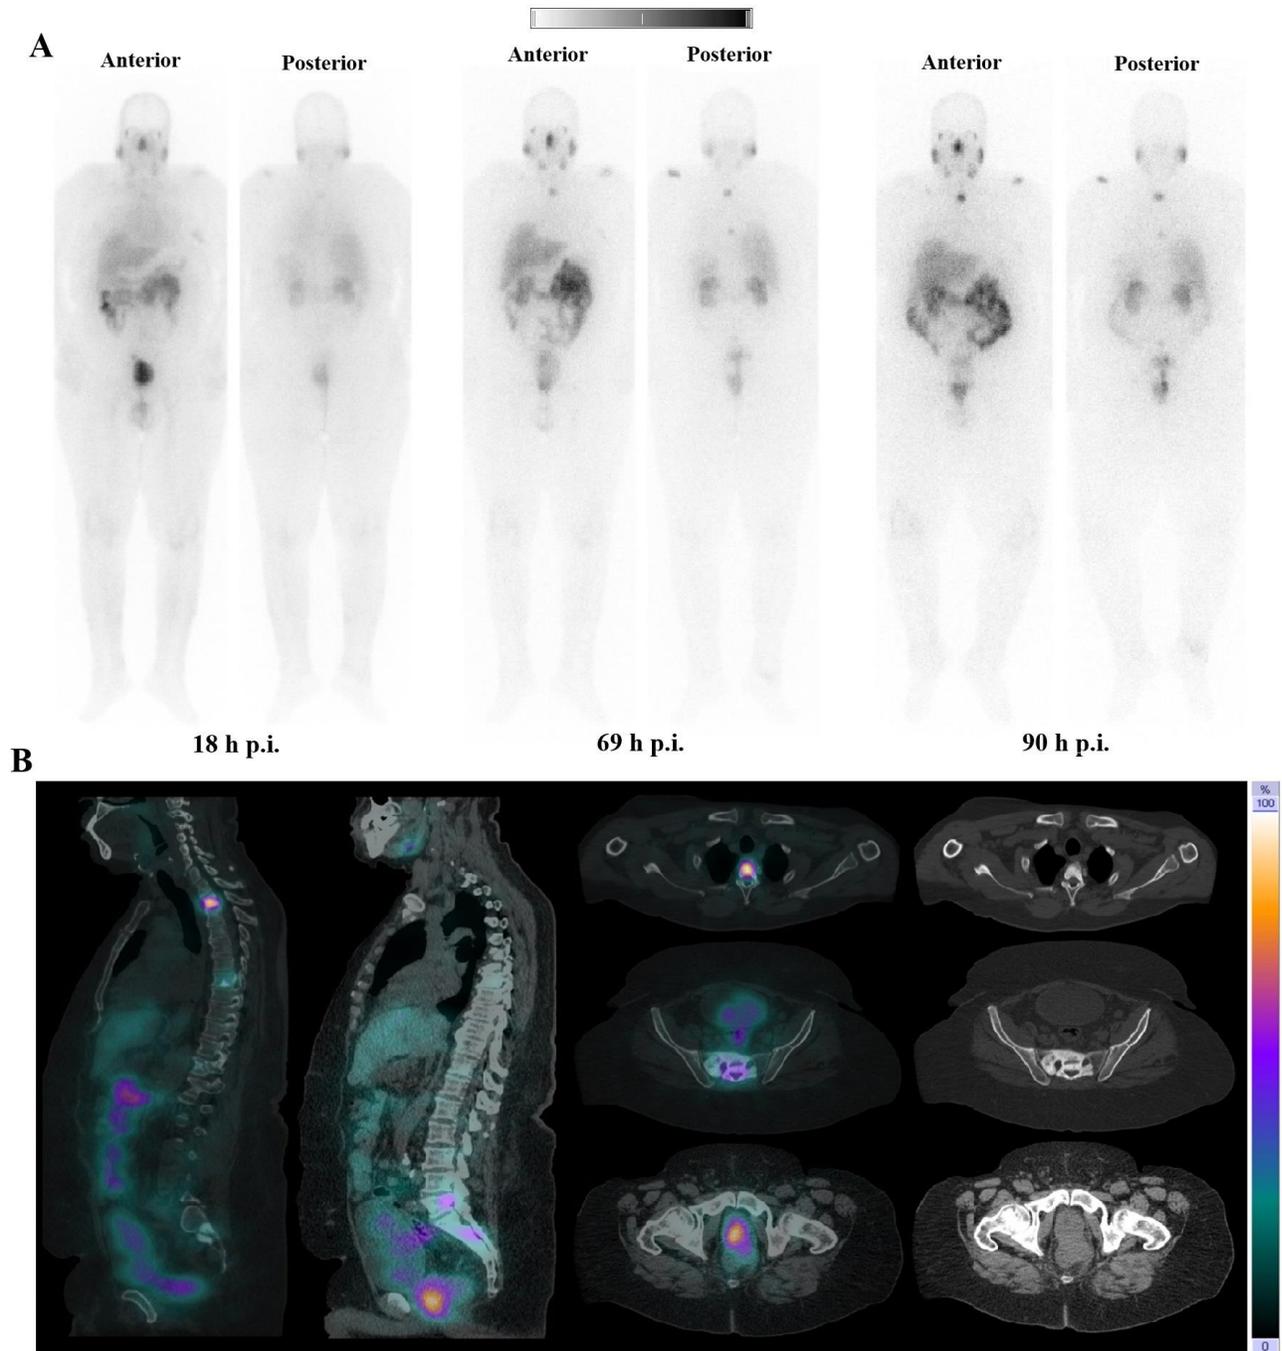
Different time points whole-body images (A) and 69h p.i. SPECT/CT representative fused sagittal, axial, and CT axial slices (B) demonstrating physiologic biodistribution of ^{161}Tb -PSMA in the lacrimal, parotid, and submandibular glands, nasopharyngeal mucosa, liver, intestinal tract, kidneys and urinary bladder, as well as a pathological uptake in the primary prostate tumor and the metastatic bone lesions. p.i. = post-injection.
